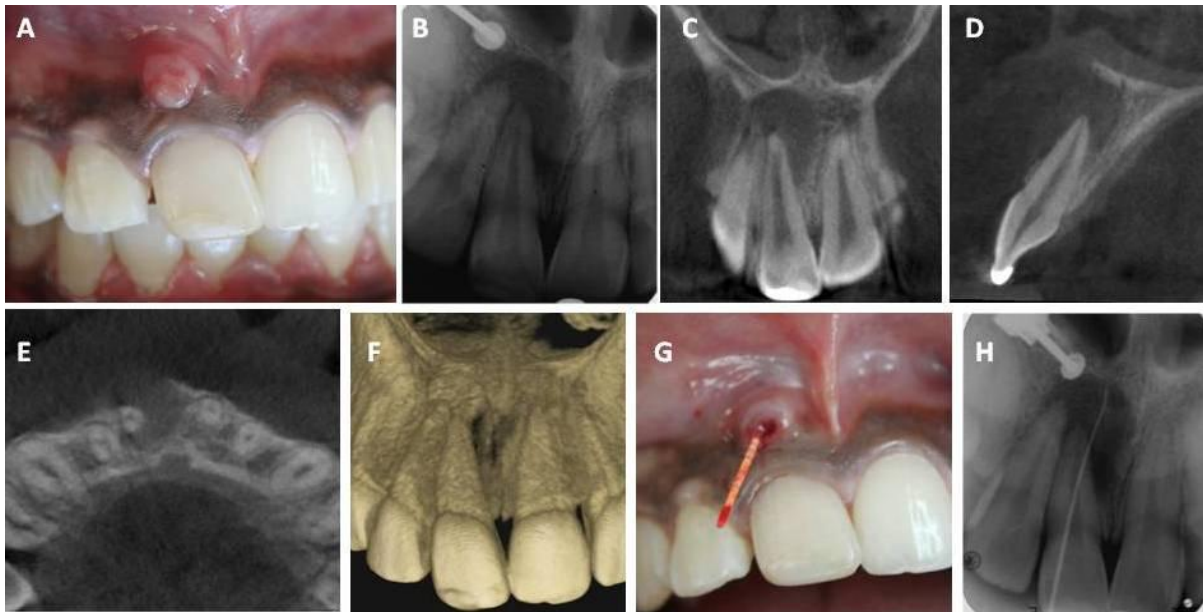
A. Pre-operative photograph showing a draining sinus tract in relation to tooth 11; B. Pre-operative IOPA radiograph showing a large periapical lesion in relation to teeth 11 and 12; C. Pre-operative CBCT image in coronal plane showing mesio-distal extent of the periapical lesion in relation to 11 and 12; D. Pre-operative CBCT image in sagittal plane showing periapical lesion in relation to 11; E. Pre-operative CBCT image in axial plane showing bucco-lingual extent of the periapical lesion; F. Pre-operative three-dimensional CBCT image; G. Gutta-percha point tracing of the sinus tract; H. IOPA radiographic view confirming relation of sinus tract to 11.
